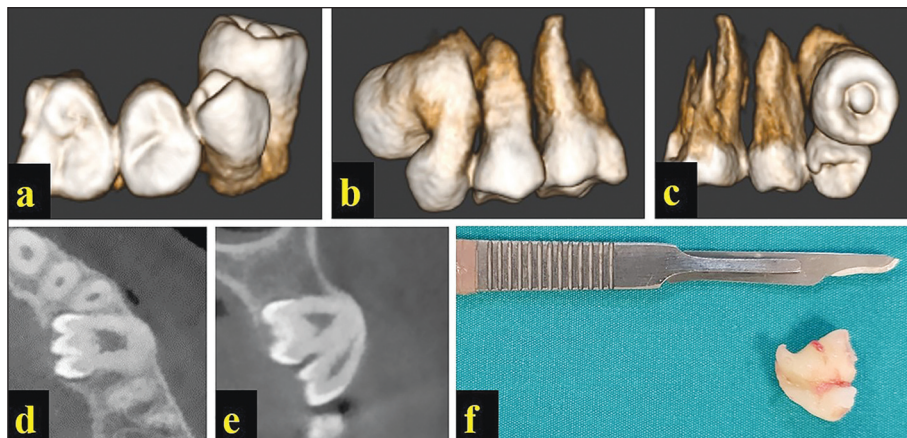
The fusion of the maxillary left first premolar and the supernumerary tooth with dense evaginatus, shown on three-dimensional reconstruction images [(a) inferior view, (b) buccal view, (c) palatal view] axial slice (d), cross-sectional slice (e) of cone-beam computed tomography, and post-surgery photograph (f).
